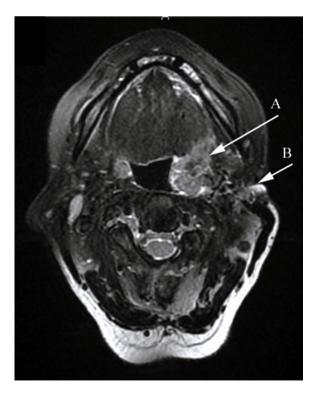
Pre-operative head and neck MRI imaging. Fat saturation T2-weighted image. (A) Tonsil squamous cell carcinoma and (B) squamous cell carcinoma of the parotid region, both occurring 20 years after radiotherapy (55 Gy) for the treatment of a recurring pleomorphic adenoma.
